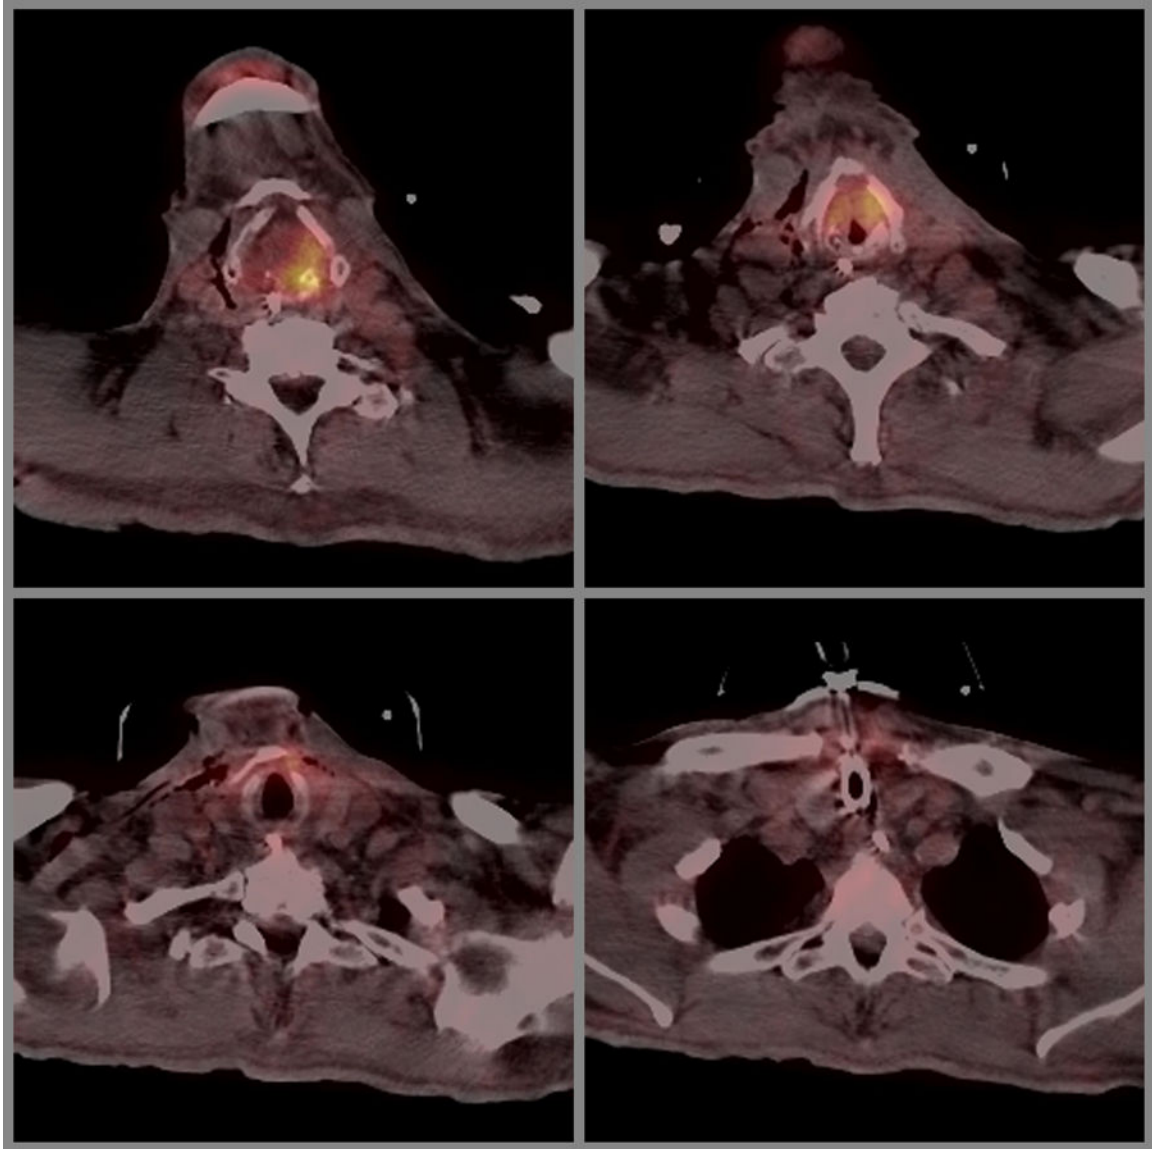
Representative images from a false negative PET-CT (patient number 3 in Table 6). Final pathology revealed 29 positive nodes.
